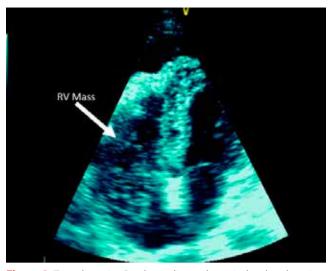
Transthoracic 2D echocardiography, apical 4-chamber view showing a mass in the right atrium extending into the right ventricle
